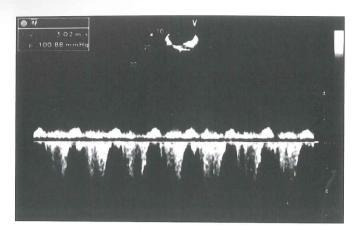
Initial echocardiogram of the patient. Pulmonary arterial systolic pressure was measured as 115mmHg.
